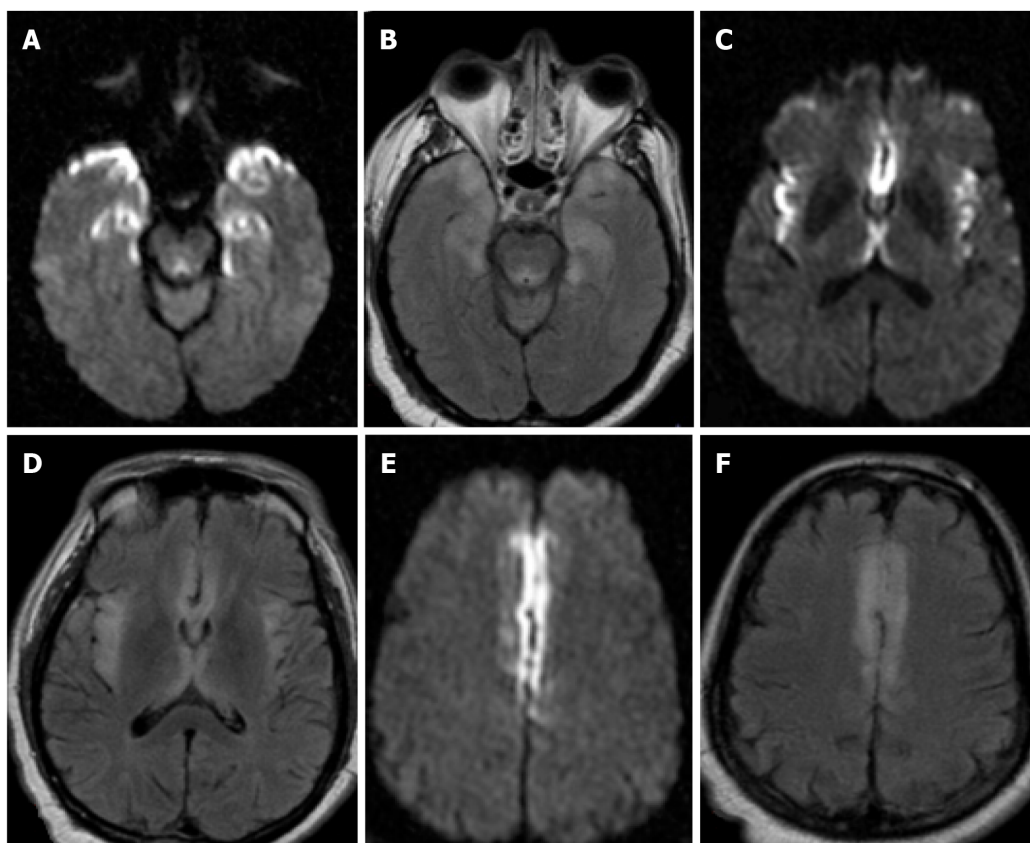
Encephalopathy. A-F: Axial DWI (A, C and E) and FLAIR (B, D and F) sequences from a brain MRI in a 49-year-old - male who was admitted for acute hypoxic respiratory failure secondary to severe acute respiratory syndrome coronavirus 2. A brain MRI was ordered 3d after presentation for progressive lethargy. There were multifocal symmetric areas of restricted diffusion and T2/FLAIR prolongation in bilateral mesial temporal lobes (A and B), insular cortex (C and D), and cingulate cortex (E and F). Cerebrospinal fluid analysis was negative. The patient's mental status gradually returned to baseline after medical management. Findings were attributed to COVID-19 – related encephalopathy.
